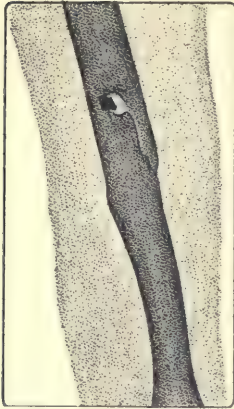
Radiograph of the right arm seen from its posterior aspect. A shell splinter is visible and is seen in the shadow of the humerus at the level of a cavity (clear zone), without doubt hollowed by the projectile at the moment of its penetration. The diaphysis of the bone was split from that point, and one can still see the presence of this fissured fracture united with slight deformity. The persistence of suppuration, the X-ray aspect of the osseous cavity, hardly half filled up by calcified tissue one year after the wound, allow the supposition that the process of osteomyelitis, although *clinically* stopped, is yet still latent, and that the extraction will determine its recrudescence, which in fact frequently happens.
